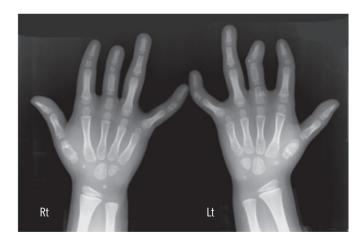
Radiographic findings of both hands at age 5 yr and 7 months. The bilateral short first metacarpals show large pseudoepiphyses. The middle phalanges of the second, third, and fifth fingers are short, with clinodactyly of the fifth fingers. The fourth fingers are unaffected. The proximal phalanges of both third fingers are short. Note the segmentation anomaly with accessory ossification along the proximal phalanx and an accessory ivory dense epiphysis at the base of the distal phalanx of the left third finger. Note the ulnar deviation of the left second finger and radial curvature of the third finger. The carpal bone age is retarded. Abbreviations: Rt, right; Lt, left.
